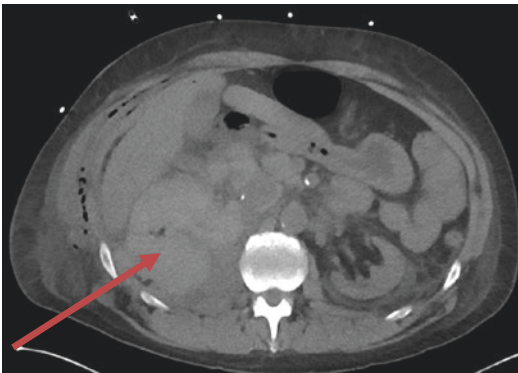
An image from the CT scan requested in Fig. 5 demonstrated hemorrhage in the right nephrectomy bed (arrow)
